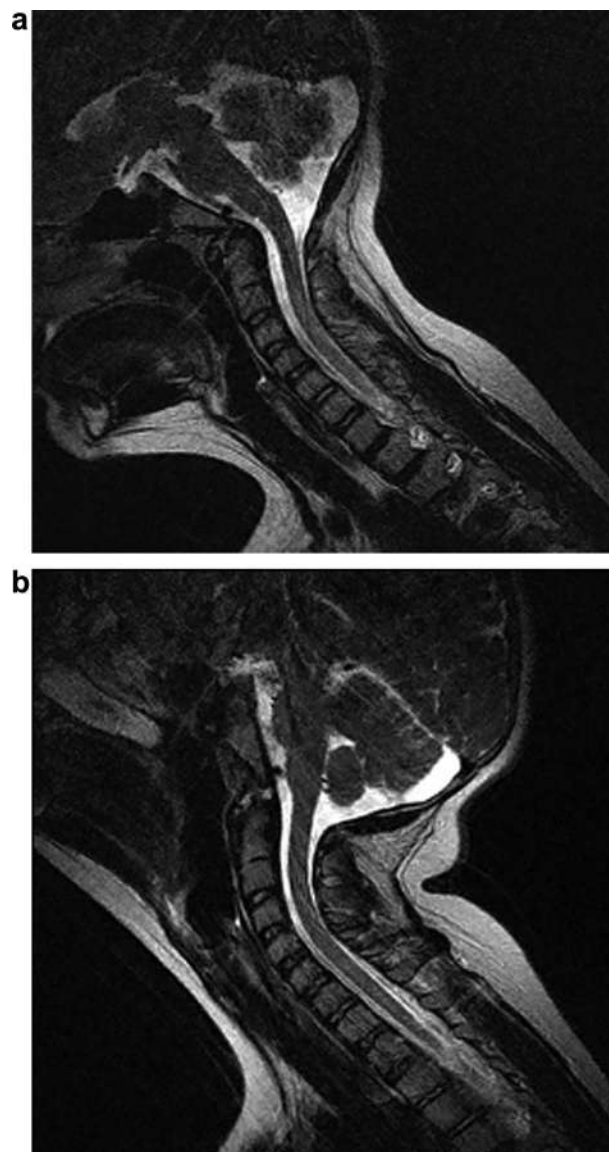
a: The craniocervical junction in flexion, showing a forward slide of the basion with respect to the odontoid (Sagittal view, T2 weighted MRI of the cervical spine in flexion). b: In extension, the basion lies along the posterior edge of the odontoid process, demonstrating a translation of 6 mm from flexion to extension (Sagittal view, T2 weighted MRI cervical spine).
